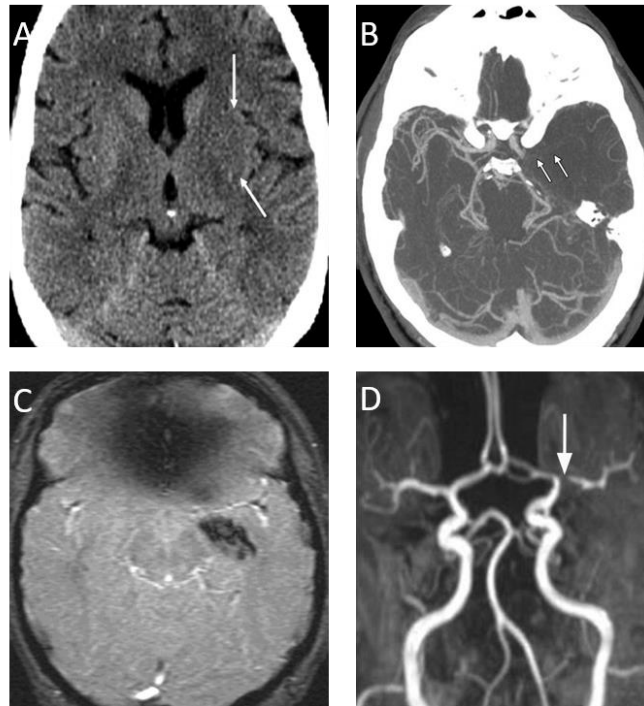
non contrast CT and MRI in ischemic stroke
